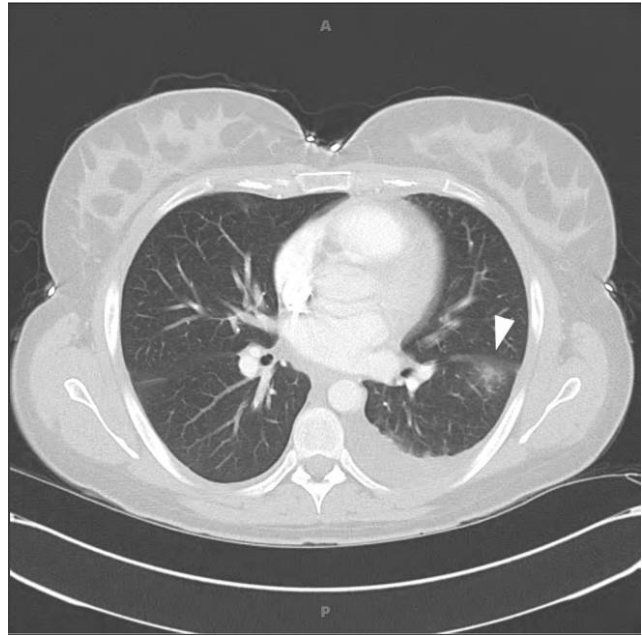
Computed tomography scan of the chest of patient 1 showing a focal consolidation in the superior segment of the left lower lobe (arrowhead) and a left pleural effusion.
